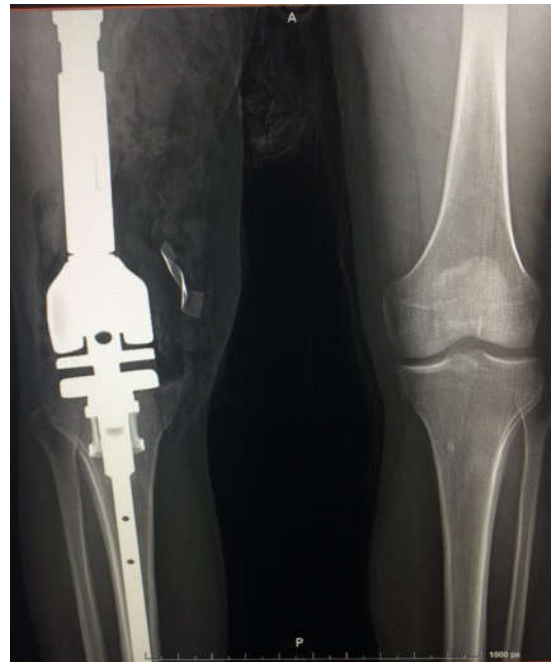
X-rays showing extensive tumor resection of the right distal femur and immediate reconstruction with unconventional tumor prosthesis
